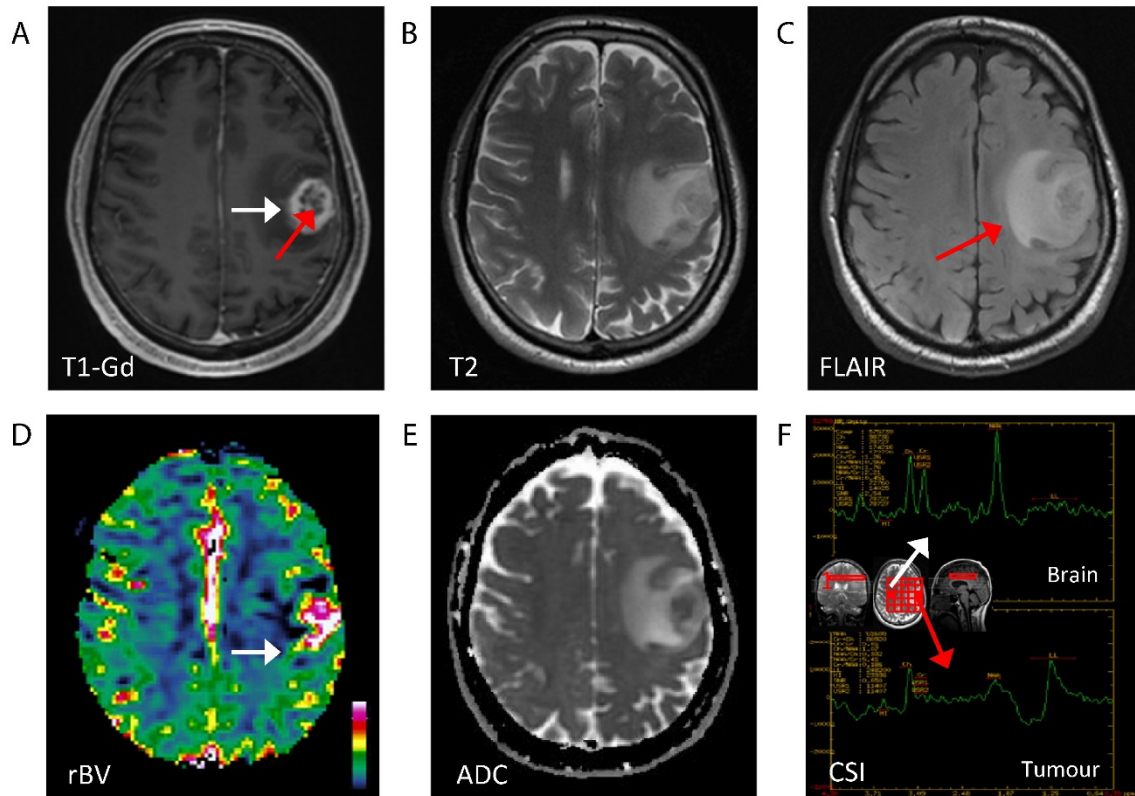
Various types of contrast generated in MRI. Pulse sequences which exploit differences in T1 and T2 relaxation are visualized in the top row: T1-weighted post-gadolinium contrast (A), T2-weighted (B), fluid-attenuated inversion recovery (C). Pulse sequences which quantify functional properties of the tumor and microenvironment are shown in the bottom row: perfusion imaging quantifying relative blood volume (rBV) (D), diffusion-weighted imaging quantifying apparent diffusion coefficient (ADC) (E), and chemical shift imaging (CSI) quantifying relative metabolite concentrations (F).
